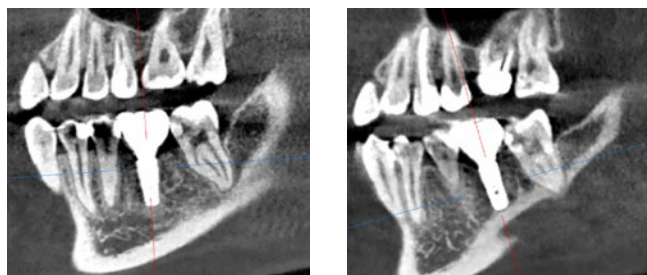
X-ray monitoring of implant placement after 6 months
